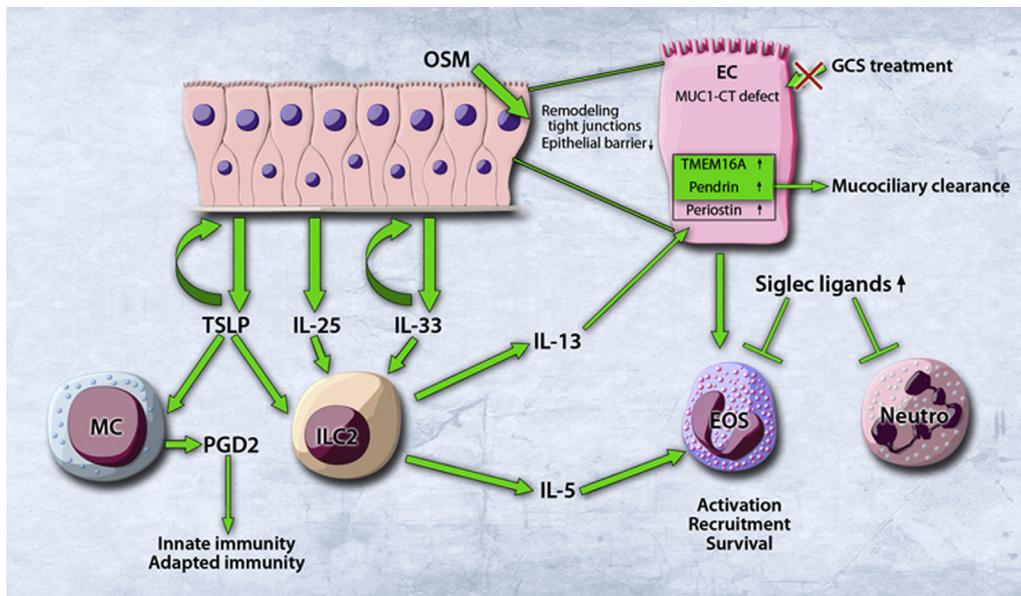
On exposure to allergens or pathogens, TSLP, IL-25, and IL-33 are produced by epithelial cells and directly act on type 2 innate lymphoid cells (ILC2), which in turn produce IL-5 and IL-13. IL-5 acts directly on eosinophils (EOS), whereas IL-13 acts indirectly on eosinophils by promoting the production of periostin in epithelial cells (EC). In addition, IL-13 increases pendrin and TMEM16 production in epithelial cells, which influences mucociliary clearance. A positive feedback loop between TSLP, IL-33, and their receptors enforces their effect. TSLP can control PGD₂ production in mast cells (MC). OSM acts on epithelial cells by affecting the epithelial barrier and remodeling of tight junctions. A defect in MUC1-CT, which was produced by epithelial cells, can cause failure of glucocorticoid (GC) treatment. Siglec ligands are upregulated in disease conditions and have an inhibitory effect on eosinophils and neutrophils (Neutro).
